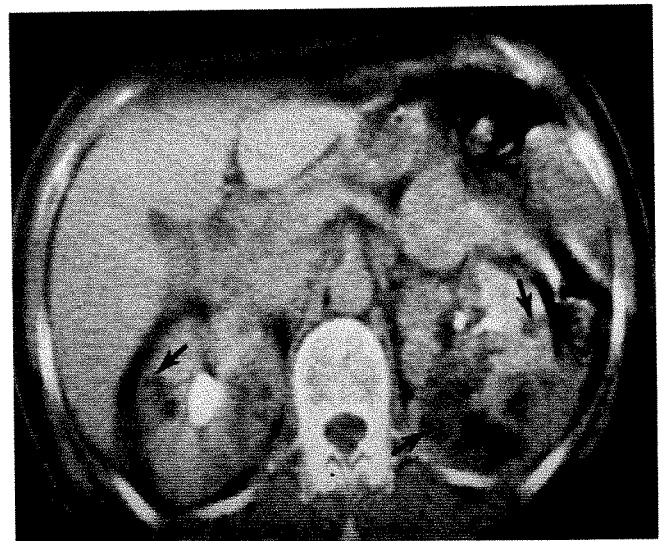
65-year-old woman with left flank pain. Urography demonstrated large left renal mass with suggestion of splaying of right pyelo-calycal system; renal angiography interpreted as showing bilateral renal cell carcinoma. CT scan performed after angiography to assess extent of neoplasm demonstrated multiple masses of low attenuation coefficients (arrows; -10 EMU units) within both kidneys. CT findings of fat density within kidneys changed presumptive diagnosis from carcinoma to angiomyolipomas; confirmed by surgical biopsy of left kidney.
